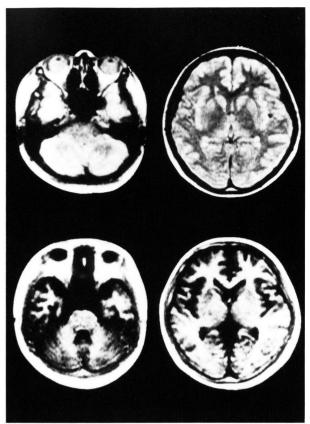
MRI scans obtained on the 15th day of admission demonstrated complete disappearance of abnormal intensity areas, better visualizations of sulci, and mild enlargement of lateral ventricles compared to the size on the admission day.
